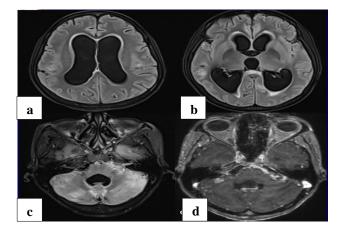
HIV positive patient presented with altered sensorium with a CD4 count of 250 U. Patient also had tuberculosis on ATT for 4 weeks and HAART for 2 weeks after initiation of ATT. Ill-defined patchy areas of T2/FLAIR hyperintensity in subcortical white matter. There is communicating hydrocephalus due to cisternal exudates. Punctate enhancement is noted in bilateral cerebellar hemispheres.
